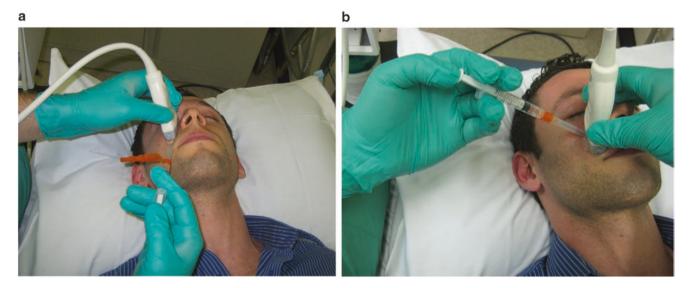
Ultrasound-guided infraorbital nerve injection technique (a) Example of in-plane needle position, (b) example of out-of-plane needle position
